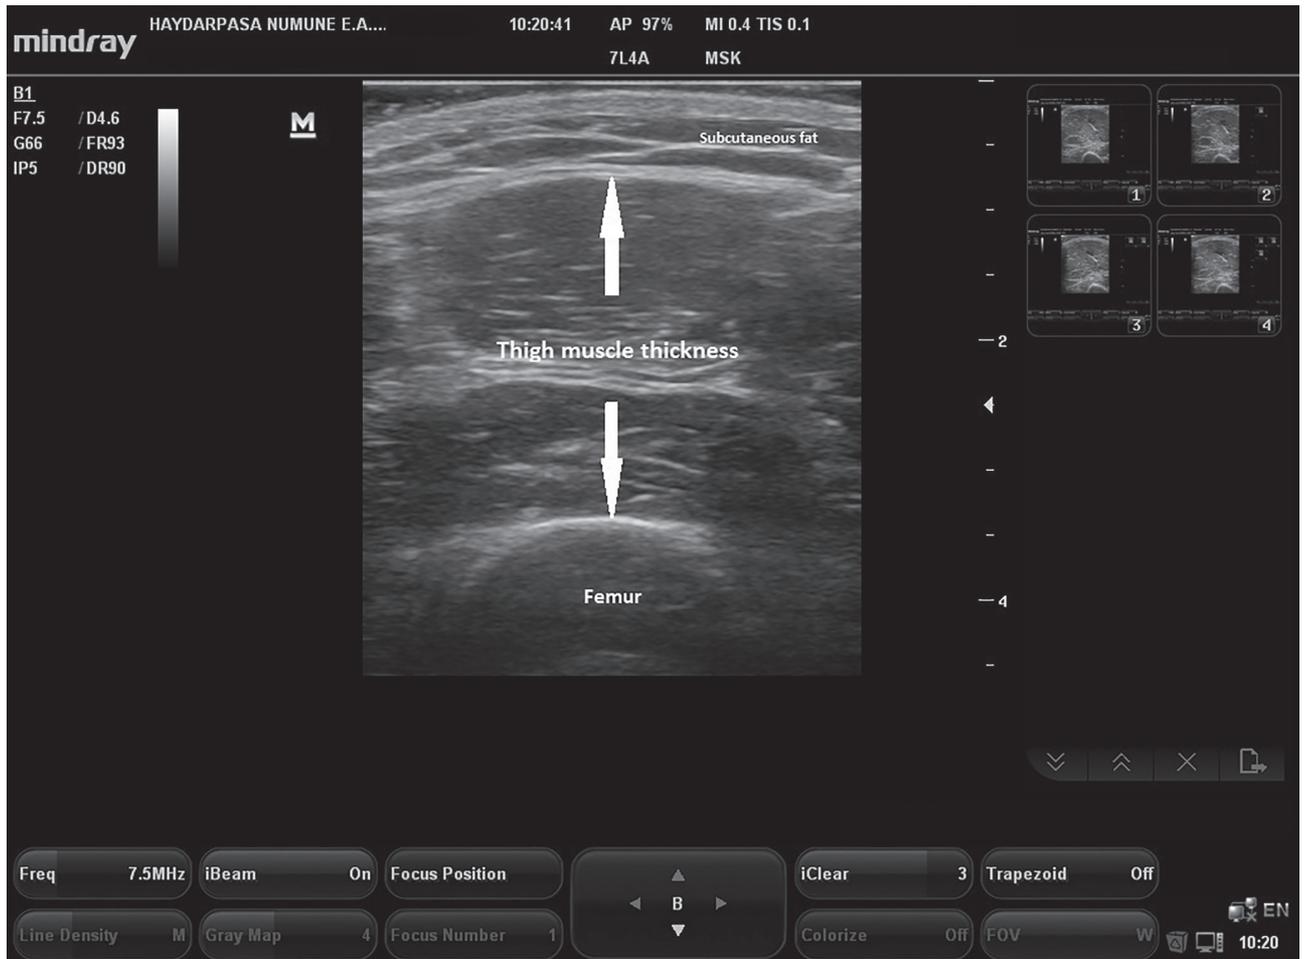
Ultrasound measurement of thigh muscle thickness.
